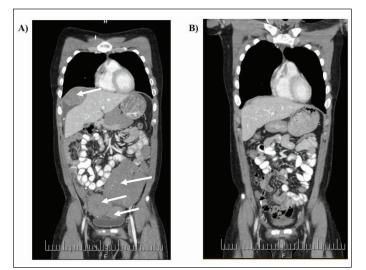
Coronal computed tomography (CT) scan images of peritoneal metastases along course of ventriculoperitoneal shunt (A) before and (B) after salvage chemotherapy. Arrows indicate metastatic lesions.
